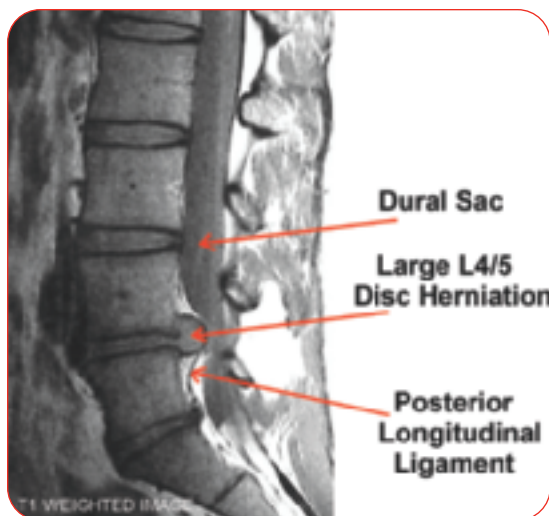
Magnetic resonance imaging. This magnetic resonance image depicts a large L4–L5 disk herniation.
